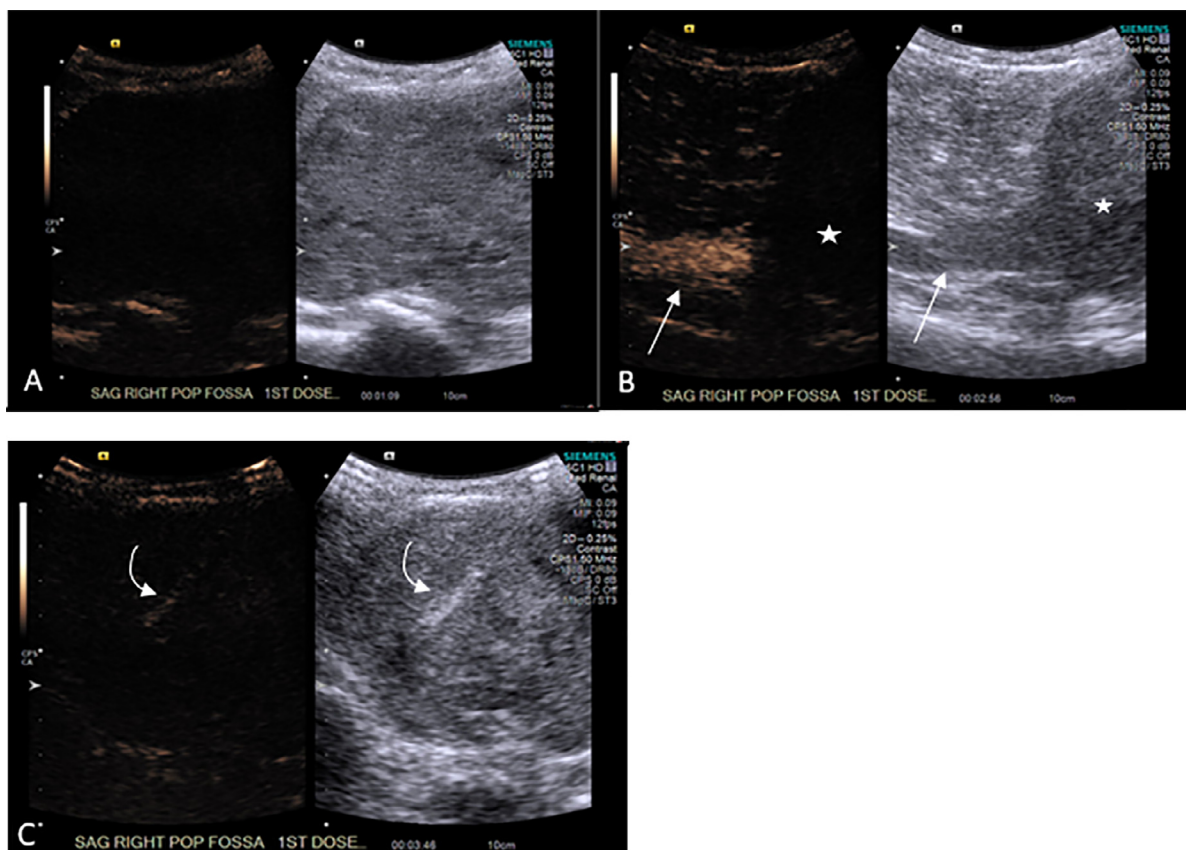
Contrast enhanced ultrasound images. (A) Early images show no enhancement within the heterogeneous lesion on the contrast only (left) image, a “black-hole.” Right-sided low MI grayscale image shows that the main portion of the heterogeneous lesion was being imaged. (B) Confirms enhancement within the proximal popliteal artery (arrow) and soft tissues proximal to the lesion. No flow was seen in the popliteal artery deep to the lesion (star), or within the lesion. (C) Linear pseudoenhancement within the lesion (right) from a bright, linear acoustic interface that is also seen on grayscale (curved arrow). Flash, or burst technique was used to reperfuse this area to prove this was pseudoenhancement and not true enhancement (not shown).
